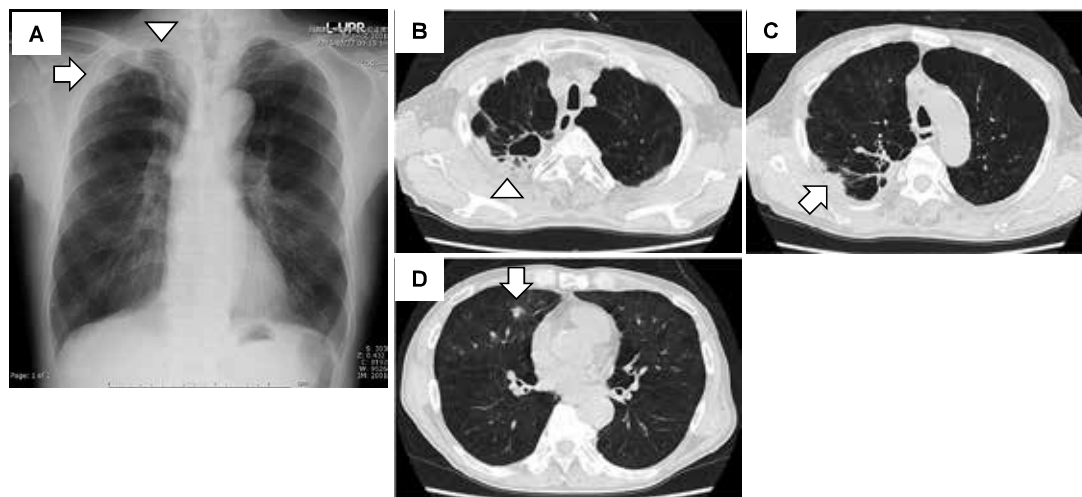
Images of chest X-ray and chest CT scan after treatments for pulmonary *M. heckeshornense* infection and lung adenocarcinoma. Radiological findings of the lesions of pulmonary *M. heckeshornense* infection (arrowheads) and lung adenocarcinoma (arrows) improved in chest X-ray (A) and chest CT (B-D).
